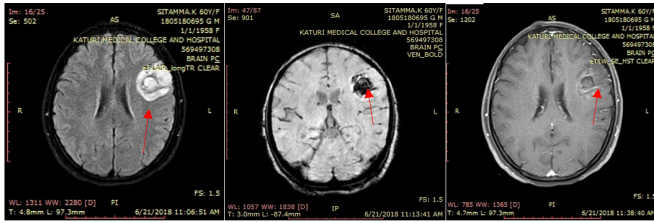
A – Axial FLAIR image showing well-defined cortical based intra-axial predominantly hyperintense lesion (arrow) with no perilesional edema. B - Gradient echo image showing hypointense signal (arrow) in the lesion. C – T1 post contrast image showing no significant enhancement (arrow).
